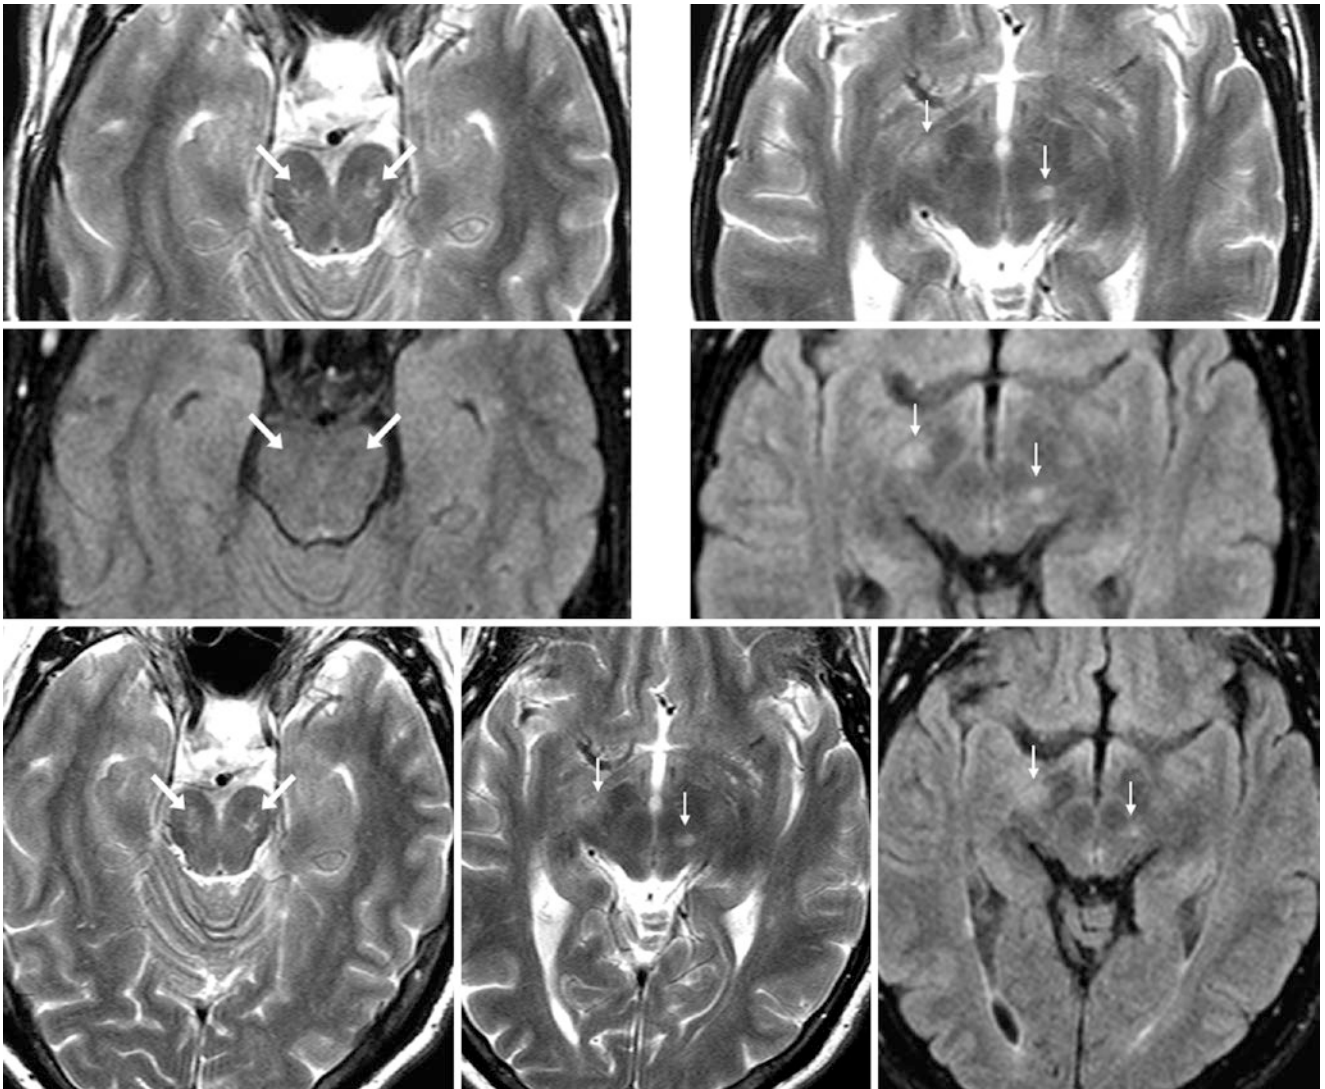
Comparison case of MS plaques within the midbrain and dilated PVSS. A 42 year old with MS. *Top row:* there were dilated PVSS bilaterally within the midbrain and cerebral peduncles (*arrows*) on T2WI (*left*); the patient also had MS plaques (*tiny arrows*) on T2WI at another level (*right*). *Middle row:* The corresponding FLAIR images
